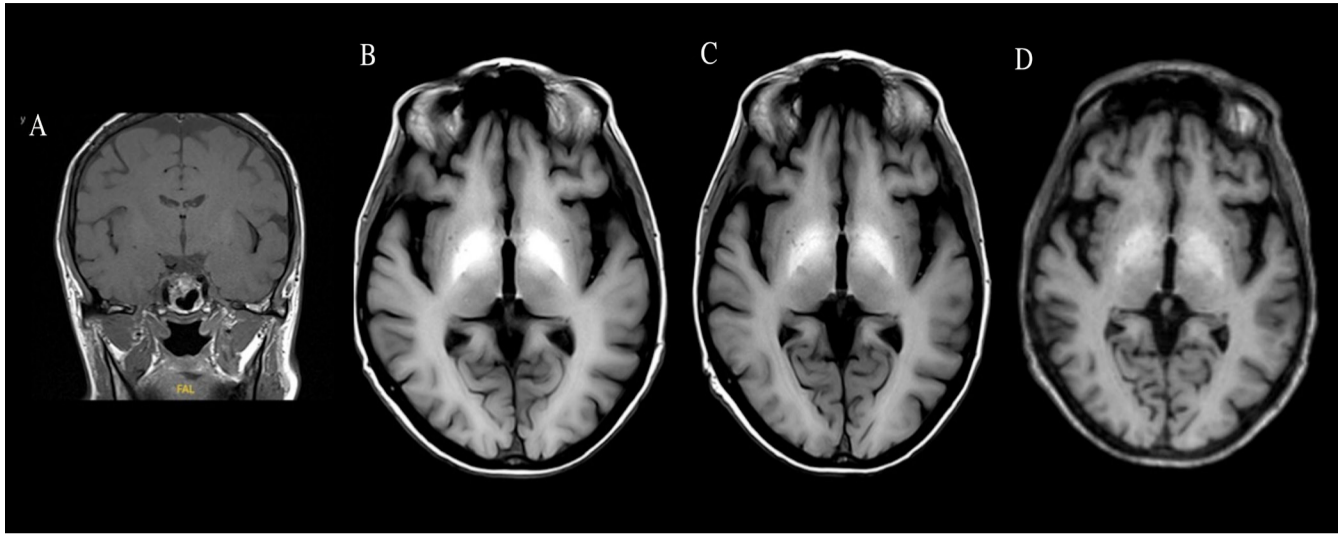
Longitudinal brain magnetic resonance imaging of the patient in T1 sequence. (A) Normal brain magnetic resonance imaging (MRI) at Langerhans cell histiocytosis diagnosis. (B) T1 weighted hyperintense signal in the pallidum at neurological onset (manganese level: 58 µmol/L). (C) Same sequence with a decrease of T1 weighted signal after six months of cobimetinib therapy and decreased blood manganese concentration (47 µmol/L). (D) Same sequence with a decrease in T1 weighted signal after 24 months of cobimetinib therapy and decreased blood manganese concentration (31 µmol/L).
